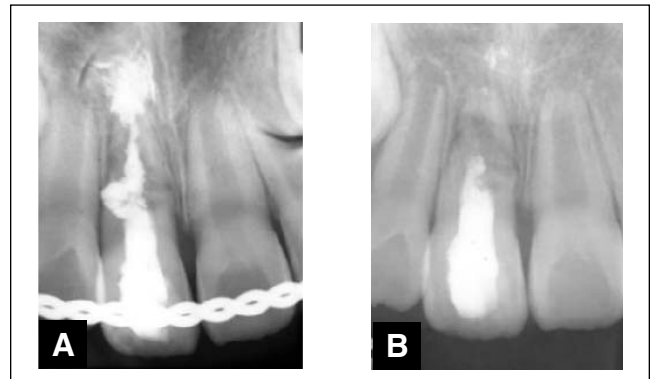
Intra-oral radiograph of maxillary anterior teeth 8 months (A) and 9 months (B) after the treatment. Note the inflammatory response.
